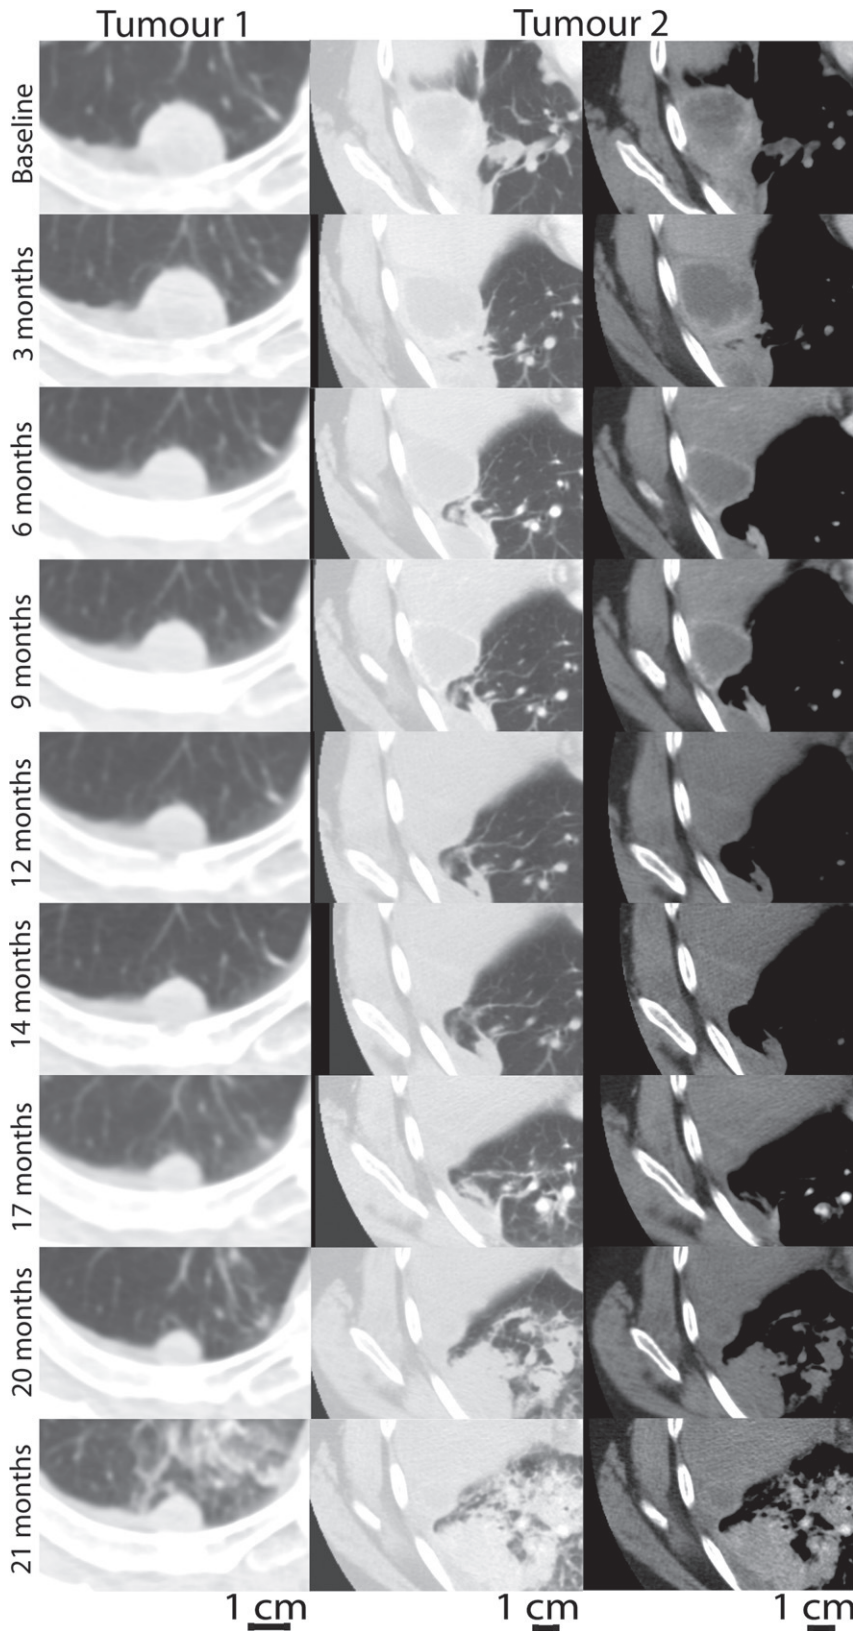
Computed tomography images of two metastatic lung tumors (*left panel*: tumor 1, lung window; tumor 2, middle, lung window, and right panel, chest window) for subject at nine time points over 2 years.
